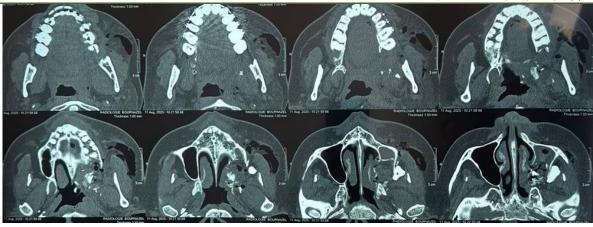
a, b and c. Dental CT scan section showing tooth 28 displaced into the retrozygomatic fat and metallic bracket within the left maxillary sinus
